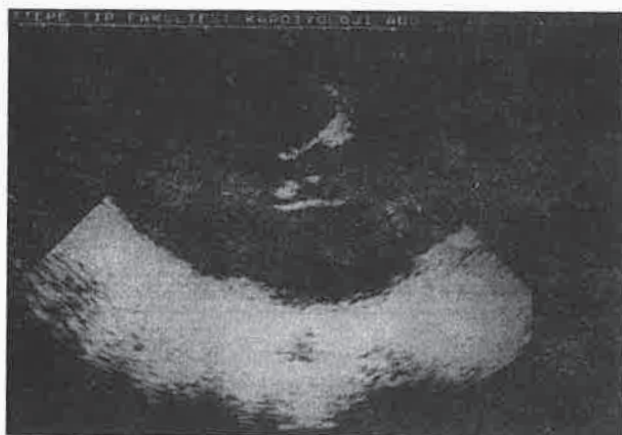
Echocardiographic examination from parasternal long axis examination reveals a large vegetation at the aortic valves
